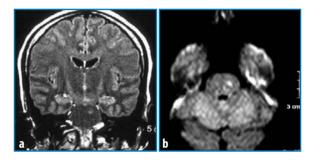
Varicella-zoster virus-related lacunar infarct in the pons. a Fluid-attenuated inversion recovery MR image obtained in the coronal plane shows a left infarct in the pons. b Diffusion-weighted MR image shows a recent ischemic stroke in the pons
